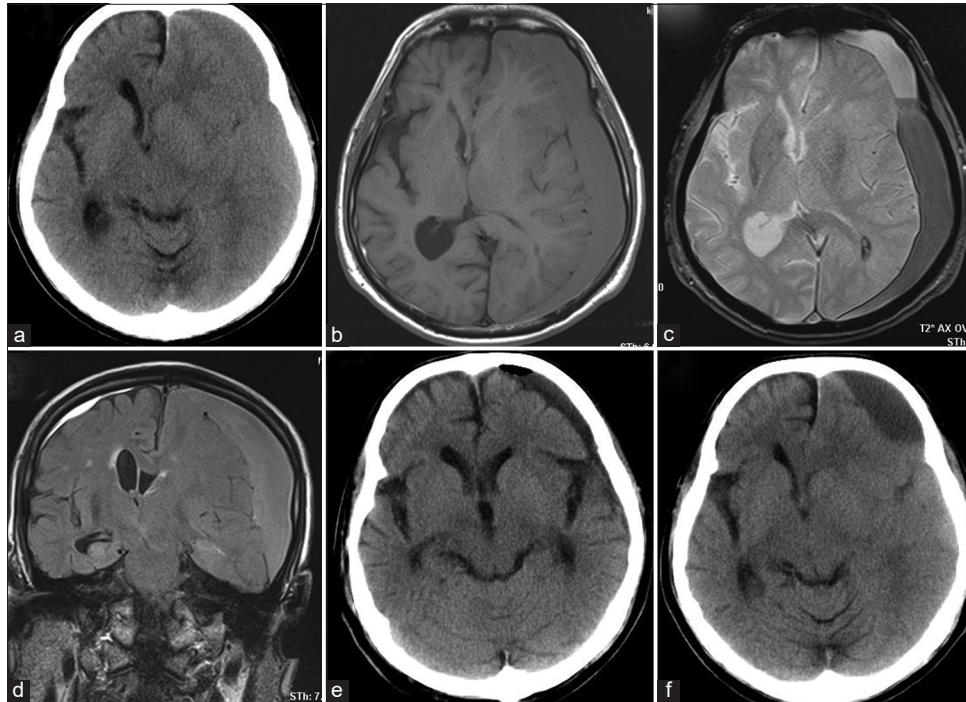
Recurrence in an 83-year-old man with bilateral CSDH (a) preoperative CT scans revealing midline shift with a hyperdense subdural hematoma, (b) hematoma showing low intensity on TIWI, (c) the presence of black bands on T2*-weighted images imply the presence of septa within the hematoma cavity, (d) the preoperative hematoma volume was 237 mL, as measured on fluid-attenuated inversion recovery coronal imaging, (e) CT scan revealing little air collection in the hematoma cavity, 1 day after surgery. The subdural hematoma drained very well. (f) The subdural hematoma recurred 23 days after surgery with right hemiparesis. CT: Computed tomography, CSDH: Chronic subdural hematoma.
